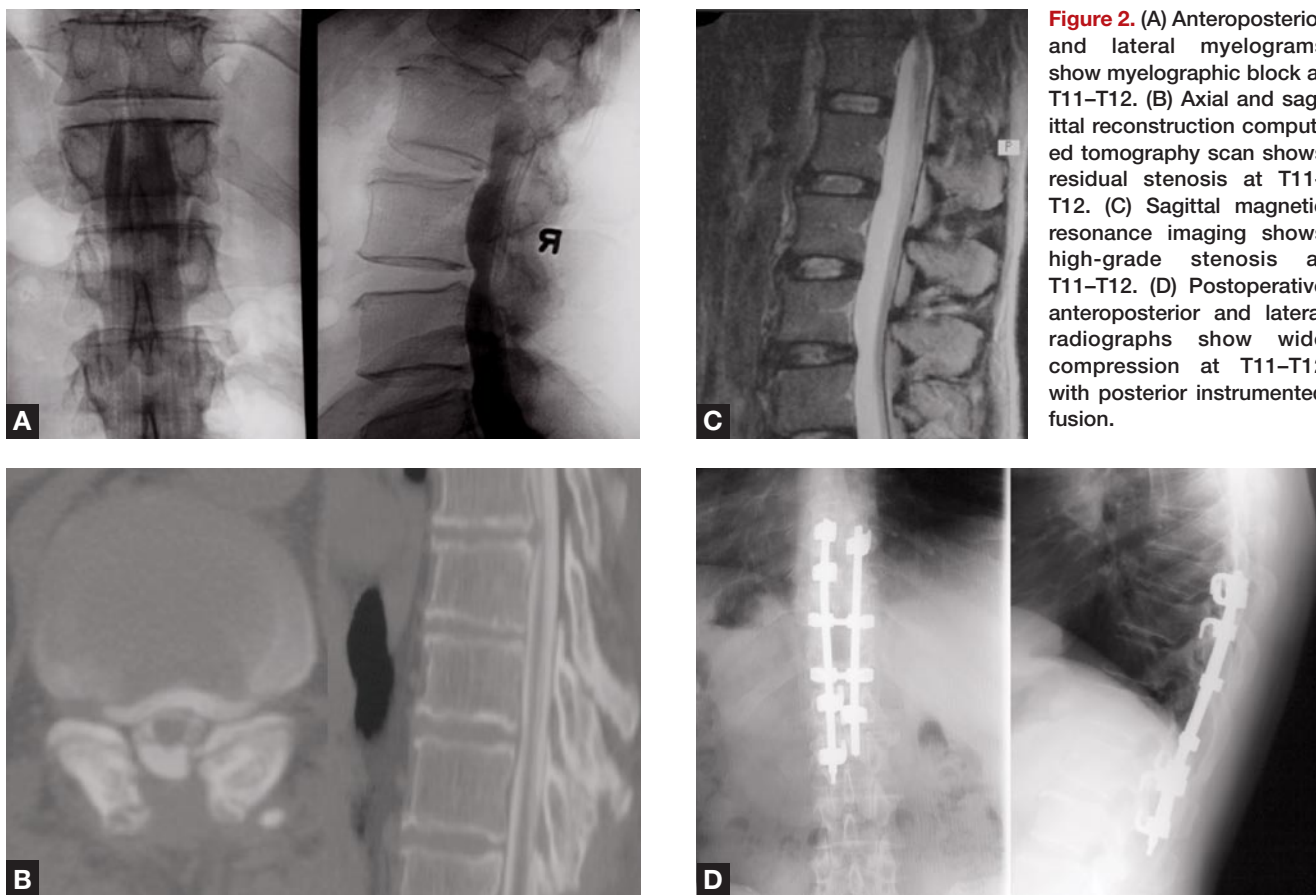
(A) Anteroposterior and lateral myelograms show myelographic block at T11–T12. (B) Axial and sagittal reconstruction computed tomography scan shows residual stenosis at T11–T12. (C) Sagittal magnetic resonance imaging shows high-grade stenosis at T11–T12. (D) Postoperative anteroposterior and lateral radiographs show wide compression at T11–T12 with posterior instrumented fusion.
